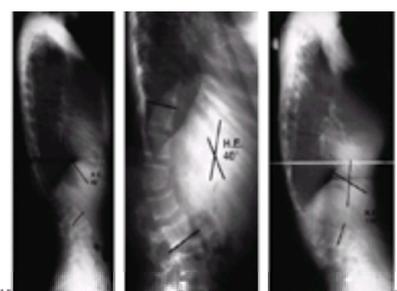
A and B: Lateral radiographs of a 17-year-old child with Marfan syndrome and a 40-degree progressive thoracolumbar kyphosis. C: Lateral radiograph of the same patient 3 years later shows that the thoracolumbar kyphosis has progressed to 110 degrees.
